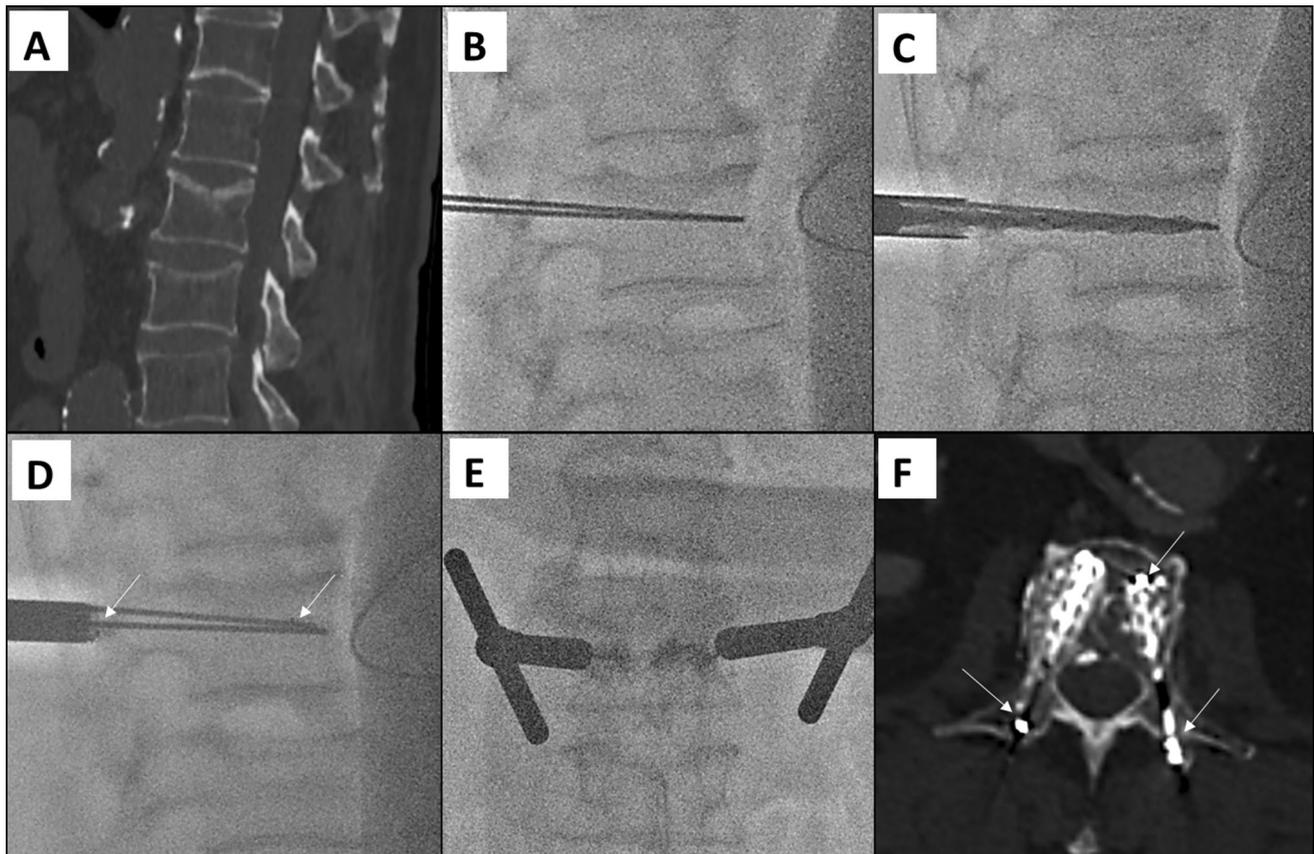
Sixty-five-year-old man with a history of lung cancer and sudden onset of severe back pain. A Sagittal computed tomography of the lumbar spine shows a Magerl IA vertebral compression fracture. B Lateral radiograph indicates the placement in the pedicle of two 2.4-mm guidewires under fluoroscopic guidance. C Lateral radiograph shows the protection tube placement using a soft tissue dilator
